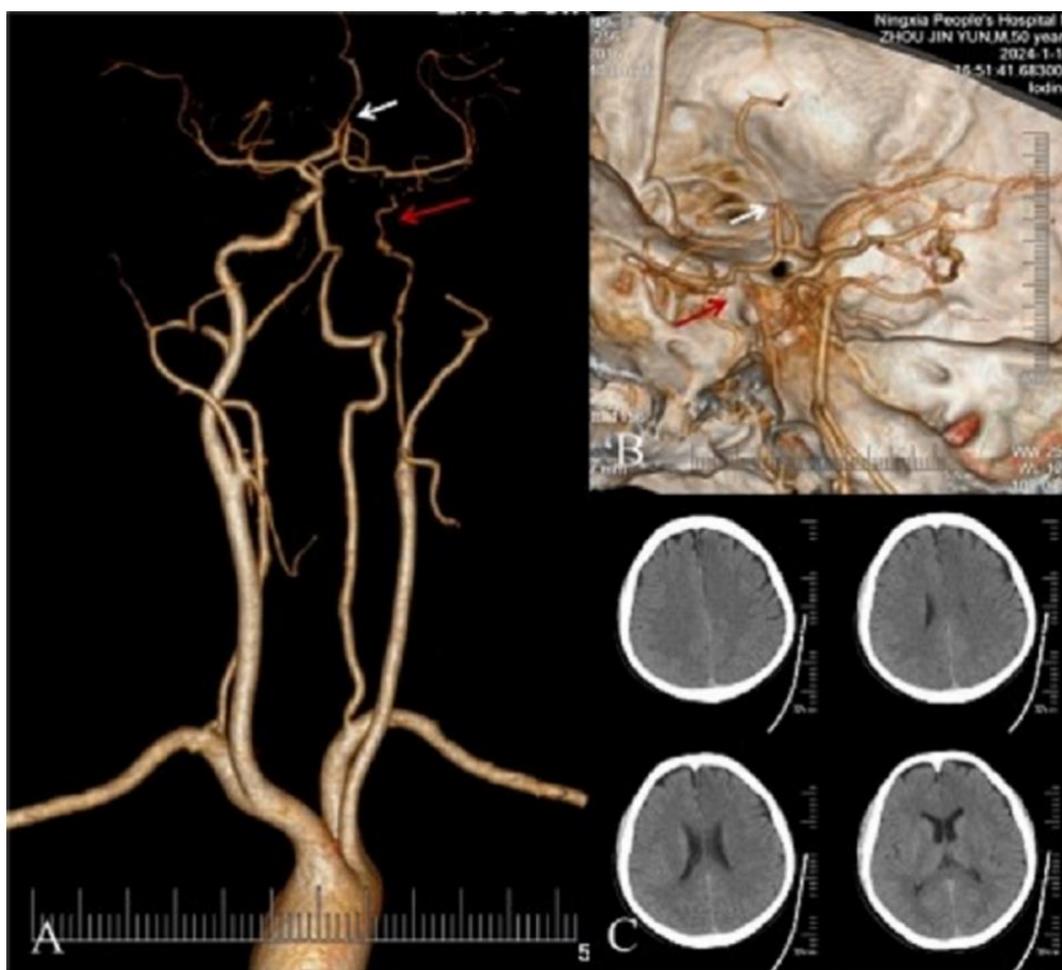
A: Chronic occlusion of the left internal carotid artery (red arrow); B: Left anterior cerebral artery A2 segment occlusion (white arrow); C: Preoperative CT plain scan indicates a local low-density lesion in the left frontal lobe.
